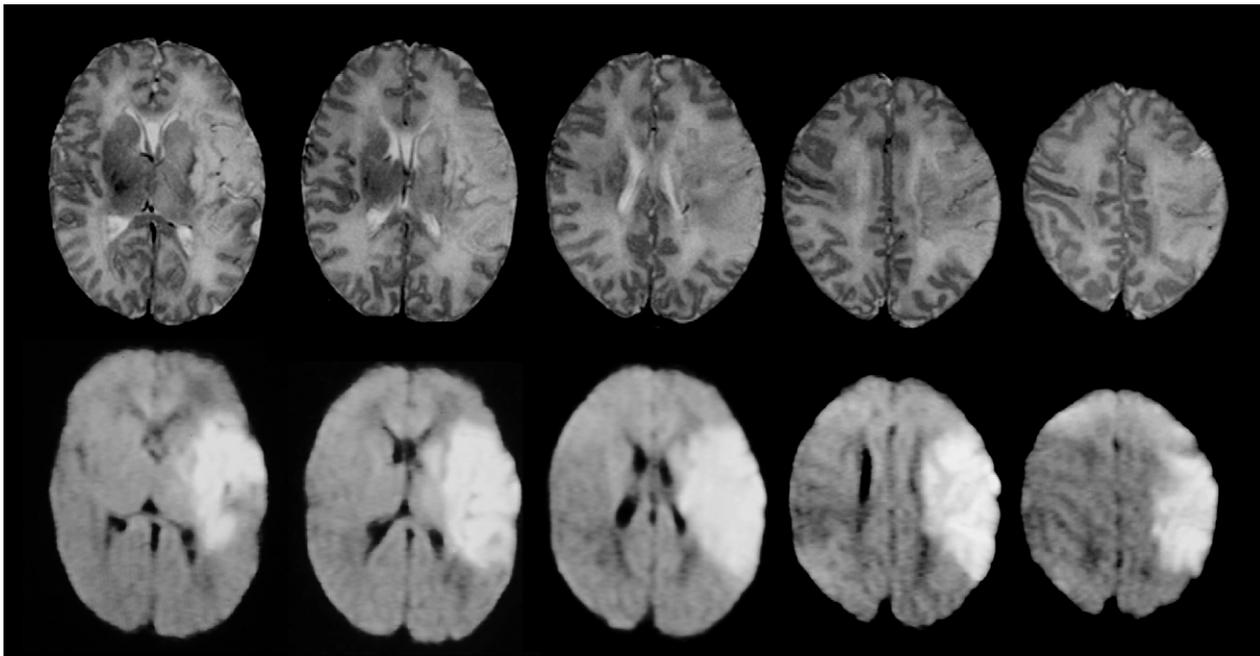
Axial T2 (TR 3500/TE 120; top) and diffusion-weighted MRI (b=1000; bottom) images of 5-day-old infant with left middle cerebral artery stroke.
